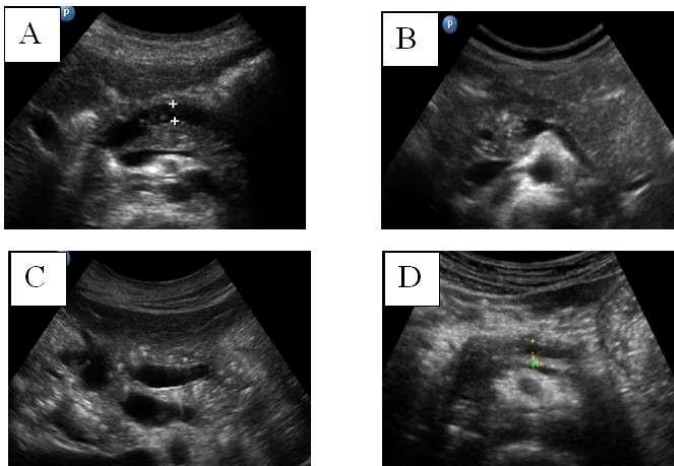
Ultrasound image of pancreas in acute pancreatitis showing bulky, hypoechoic pancreas
